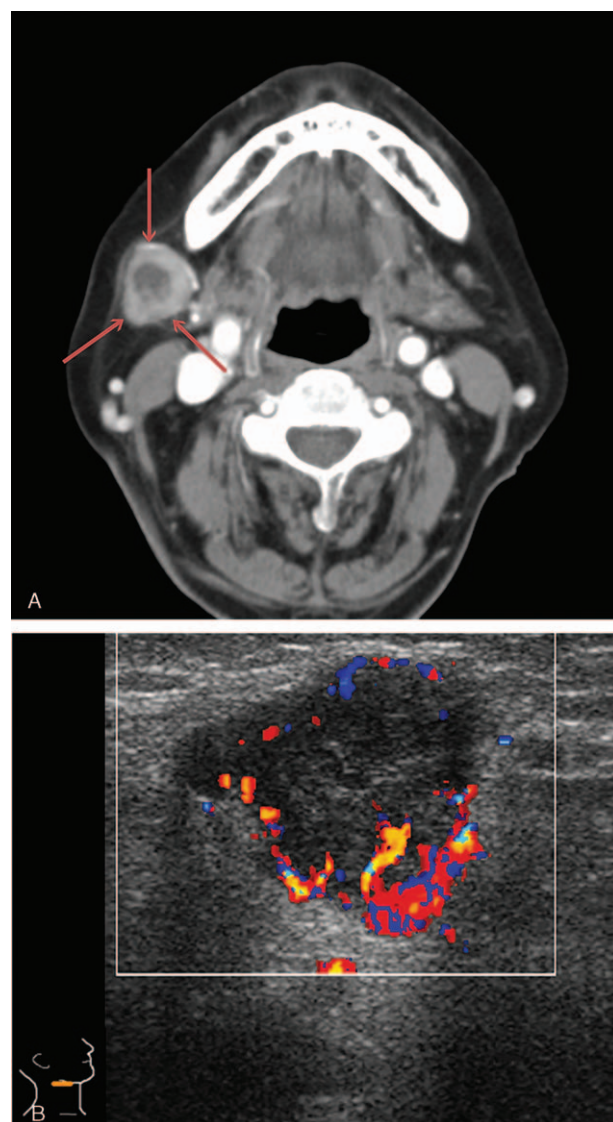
(A) A 71-year-old woman was admitted with a painful, recently growing palpable mass in the right submandibular region for 1 week. A well-enhanced solid mass with an inner cystic change is seen on the enhanced computed tomography scan. (B) Color Doppler ultrasonography shows a well-defined, lobulated hypoechoic solid mass with posterior enhancement and increased vascularity in the hypoechoic mass, abutting to the right submandibular gland.
